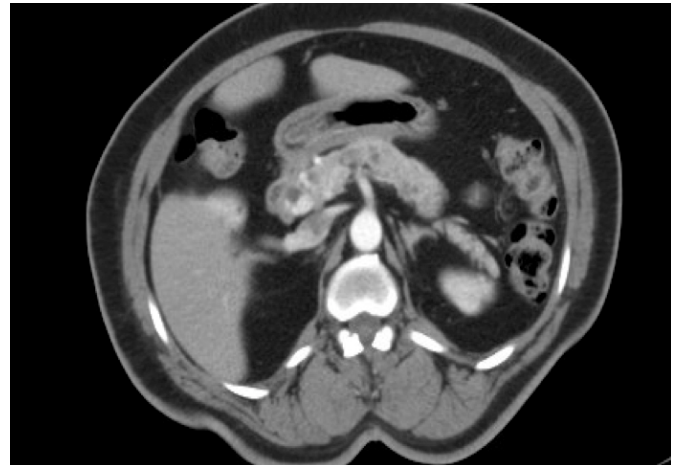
CT abdomen demonstrating 2.9 x 2.7 cm enhancing mass in the pancreatic head, multiple cystic structures within the pancreas for which intraductal papillary mucinous neoplasm is not excluded.
